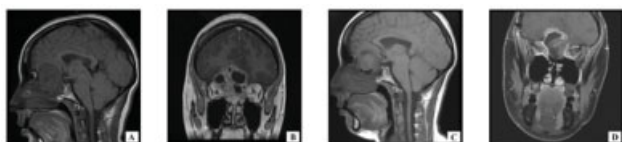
(A) Preoperative sagittal T1 MRI. (B) Preoperative coronal MRI. (C) Postoperative showing recurrent tumor and meningoencephalocele on sagittal T1 MRI. (D) Postoperative showing recurrent tumor and meningoencephalocele on coronal T1 MRI with gadolinium
